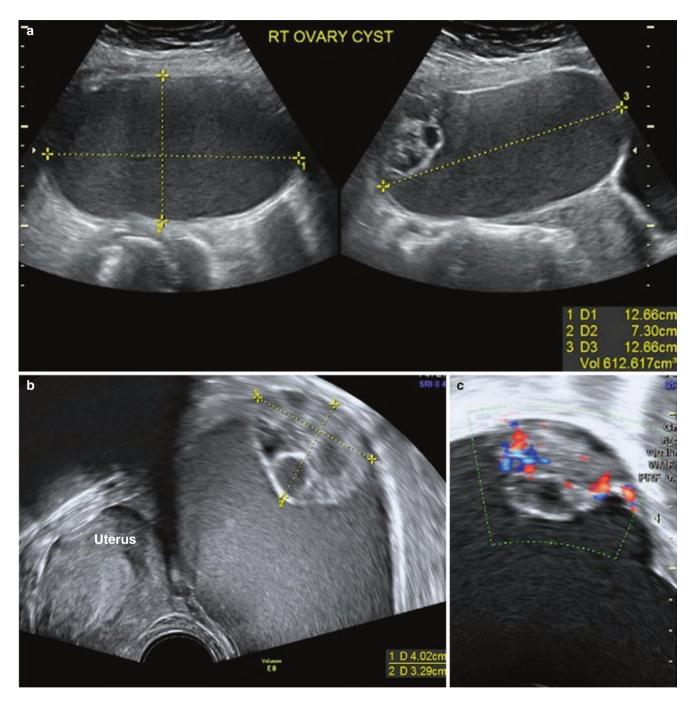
Borderline mucinous cyst with torsion. (a) Cyst showing focal area of multiple locules. (b) Cyst is seen anterior to the uterus on TVS. It shows turbid contents and a circumscribed focal multilocular area. (c) Flow is seen in this area with a colour score of 3. (d) Enlarged image of the focal multicystic area showing multiple tiny locules that are very close, giving it a solid appearance in some parts, (e) pedicle of torsed ovary showing the whirlpool sign on greyscale and Doppler (*arrows*)
